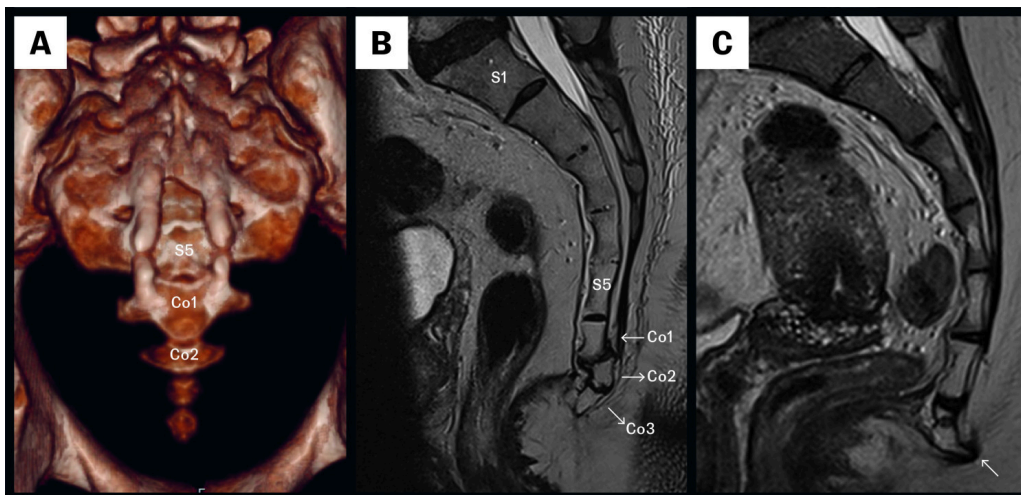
a) Normal findings with four coccygeal vertebrae displayed on a CT scan (anterior view with 3D reconstruction). Sagittal MRI of sacrum and coccyx shows b) dorsal subluxation of Co2 and Co3, and c) coccygeal spicule on the tip of the coccyx and fibrosis of the surrounding soft tissue (arrow).
